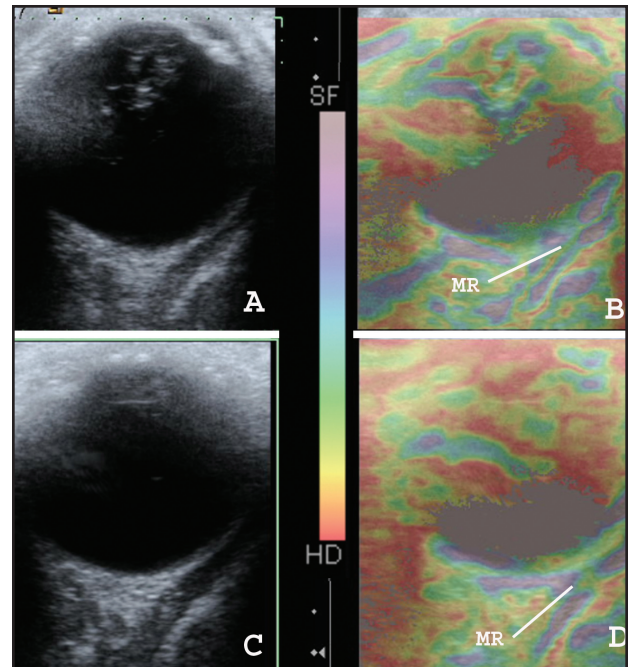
Transverse B-scan images (A and C) and respective color-coded ultrasound elastographic images (B and D) of an eye in primary position (A and B) and adduction (C and D). The central portion of the medial rectus muscle (MR) displays a different color pattern in adduction (red-yellow) than in primary position (blue-green), implying decreased elasticity in the latter condition. The color scale from blue (more elastic) to red (less elastic) is also shown.
